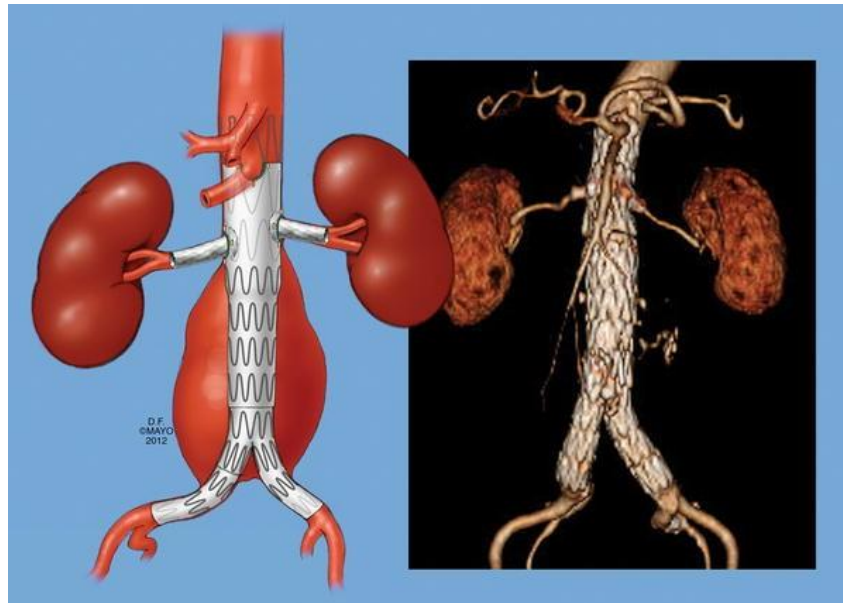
Endovascular repair of a juxtarenal abdominal aortic aneurysm with a fenestrated stent graft, and 3D reconstruction of postoperative computed tomography angiography demonstrating patency of visceral arteries and exclusion of the aneurysm sac. Image from Mendes, B.C., Oderich, G.S., Correa, M.P. et al. Endovascular Repair of Complex Aortic Pathology. *Curr Surg Rep* 1, 67–77 (2013). <https://doi.org/10.1007/s40137-013-0019-9>.
